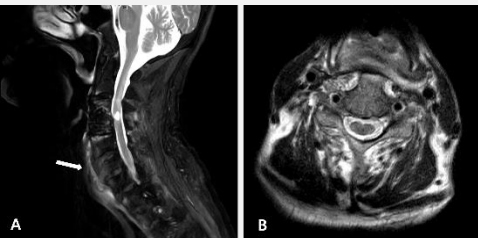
MRI of cervical spine suggesting deep neck infection. (A) Sagittal T2 weight enhanced image showing edema and soft tissue enhancement of prevertebral space of C4 to C7 (arrow). (B) Axial T2 image presenting prevertebral soft tissue enhancement and bone marrow edema at C5 level.
